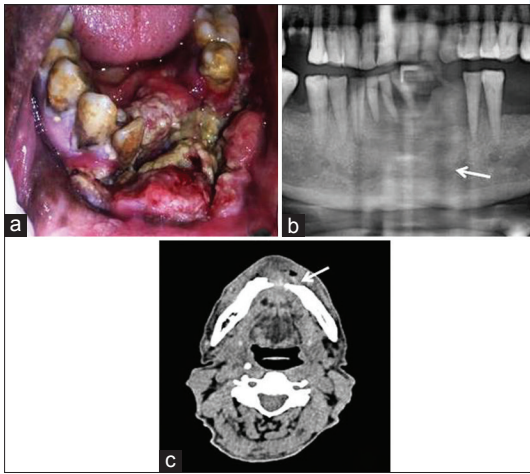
(a) An ulceroproliferative lesion in lower anterior region. (b) A panoramic radiograph showing the malignant lesion involving symphysis and parasymphysis region. (c) Axial view of CT scan showing destruction of buccal and lingual cortical plates
